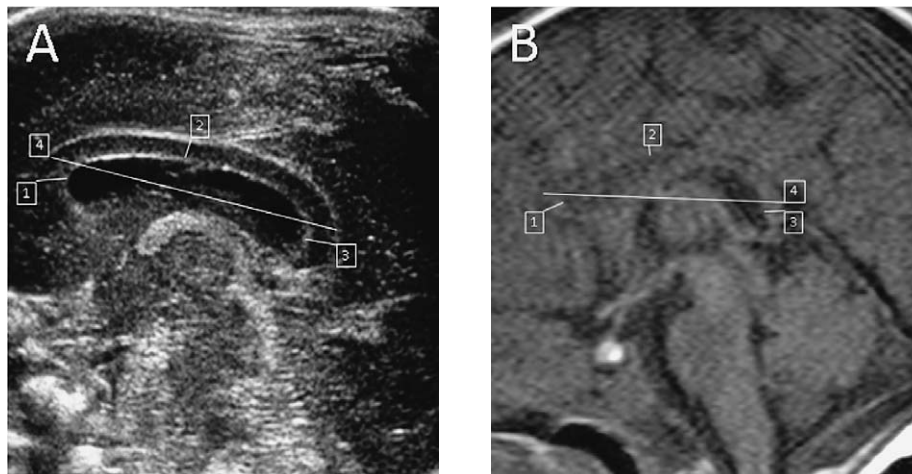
Measurement of the width of the genu (A, B-1), corpus (A, B-2) and splenium (A, B-3), and anteroposterior (AP) length (A, B-4) of the corpus callosum (CC) in the mid-sagittal plane on both coronal US (A) and MRI (B).
